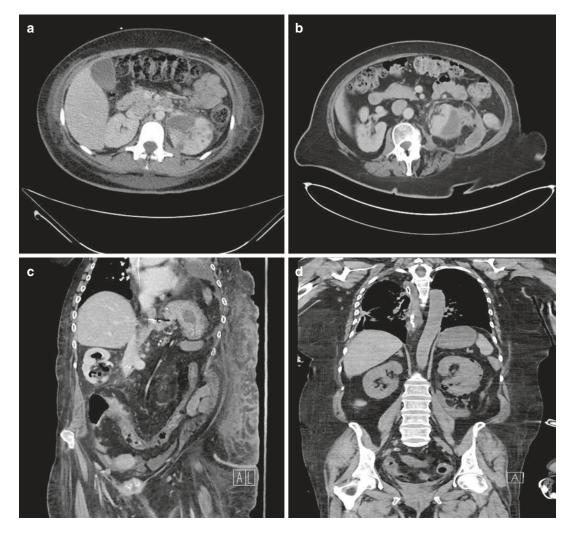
CT images showing multifocal left renal abscess (a), left perinephric abscess with expansion into Gerota's fascia (b), right emphysematous pyelitis (c), and left emphysematous pyelonephritis (d)
